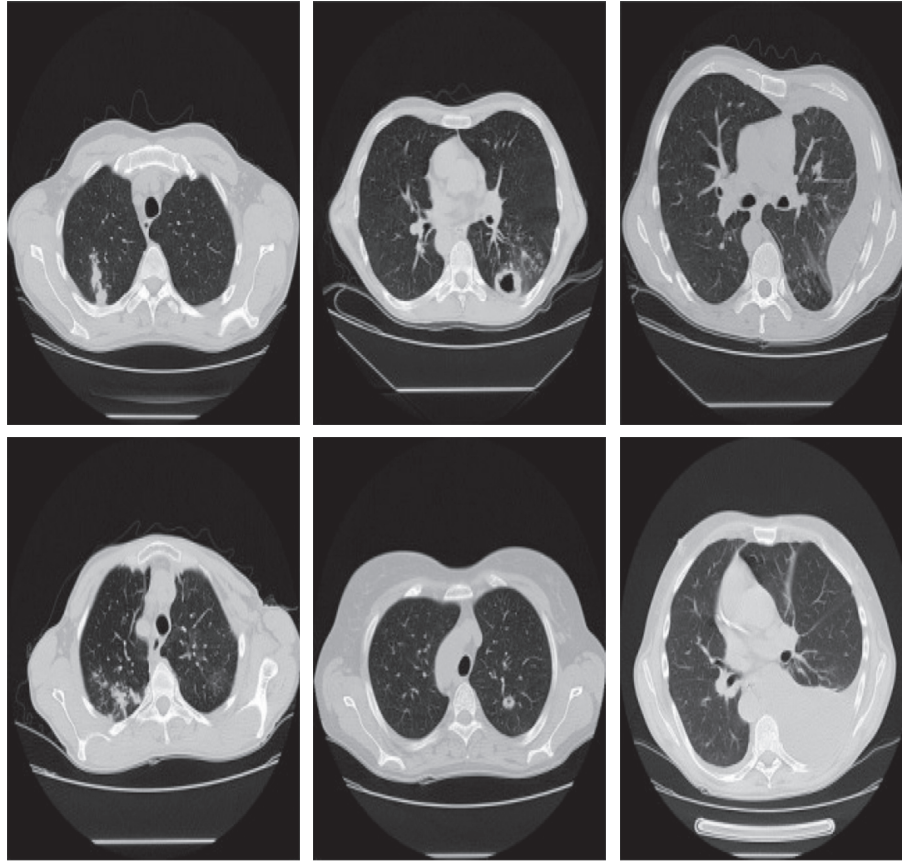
Slices of typical CT images with three types of TB-related findings (<https://www.imageclef.org/2020/medical/tuberculosis>).
